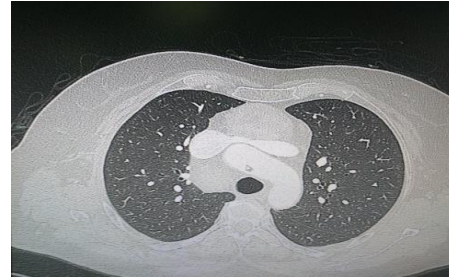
CT- Scans with pulmonary window shows the mass at the levels of aortic arch.
